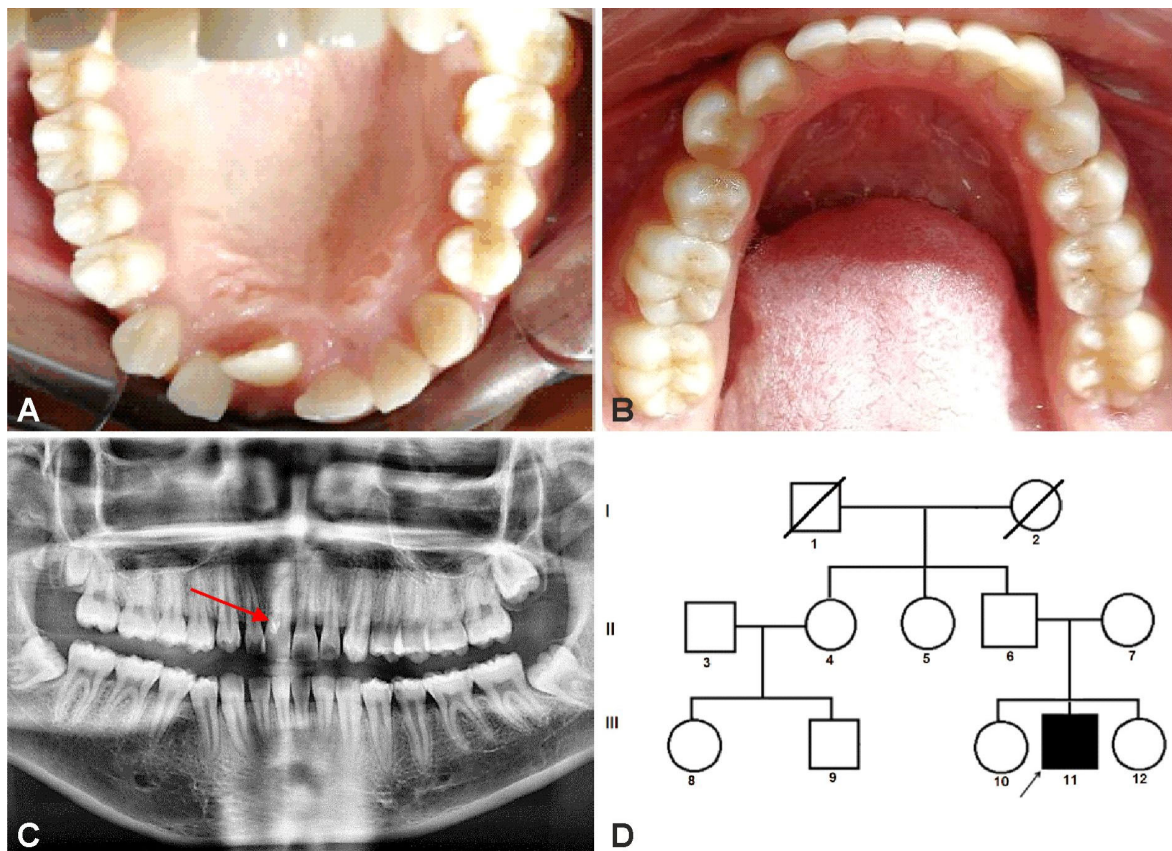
Supernumerary upper central incisor (I.1 bis) – isolated, sporadic, non-hereditary, nonsyndromic case (16-year-old boy). Intraorally occlusal views: upper arch (A) and lower arch (B) denoting the clinical dental phenotype; panoramic radiograph showing the supernumerary tooth (C); the family tree: isolated, sporadic case (D).
